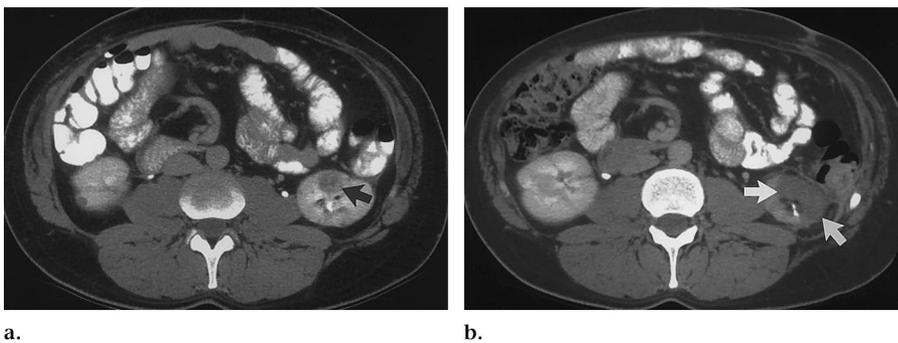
Radio-frequency ablation of renal tumor due to hereditary renal cancer in a 35-year-old man. (a) Transverse CT image demonstrates a growing solid mass (arrow) in the lower pole of the left kidney. Radio-frequency ablation was performed. (b) Follow-up transverse CT image obtained 9 months after ablation demonstrates damaged renal parenchyma (arrows) at the tumor site. Enhancement of this area was less than 10 HU. Regional defects can be seen for more than 2 years after radio-frequency ablation; however, this treatment method is much less invasive than surgery. (Images courtesy of Bradford J. Wood, MD, National Institutes of Health, Bethesda, Md.)
